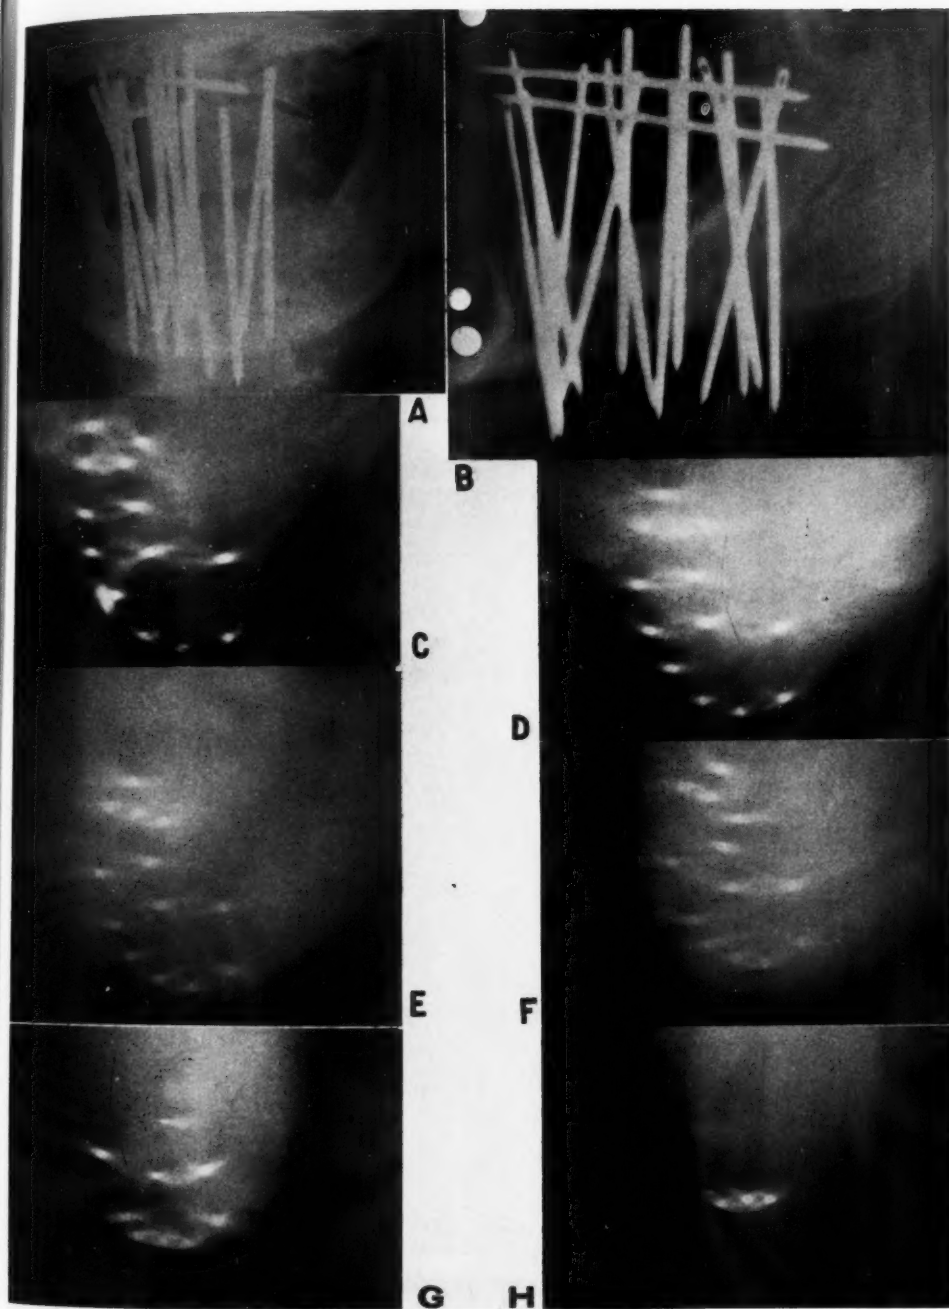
Double plane implant in tongue. A and B. Routine radiographs. C-H. Serial transverse tomographic sections.
